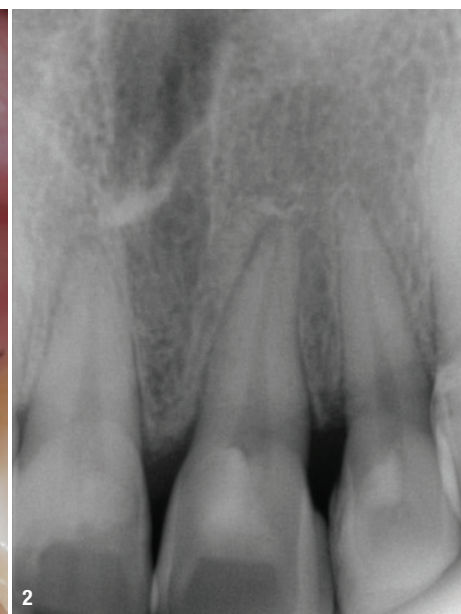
Initial clinical aspect. Fig. 2: Initial periapical radiograph.
